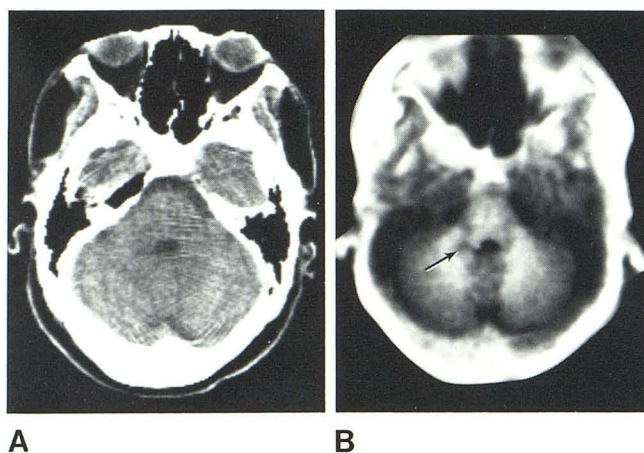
Multiple sclerosis: patient with facial myokymia. A, CT. B, IR_{1400/400}. Lesion in pons just lateral to pontomedullary sulcus within lower pontine slice (arrow).
